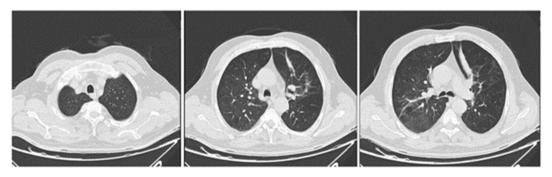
In computed tomography (CT) of the thorax, Images show widespread emphysematous areas.
